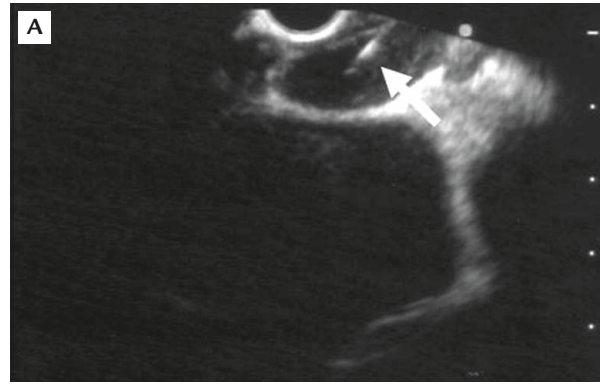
(A) Endoscopic ultrasound (EUS)-guided fine-needle aspiration with a 22-gauge needle (arrow) from mediastinal lymph nodes. (B) EUS-guided trucut biopsy with a 19-gauge needle (arrow) from a mediastinal lymph node.
